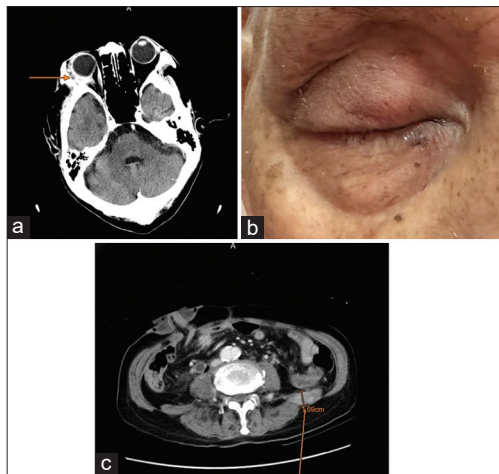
Brain computed tomography (CT) with contrast (a) and photo of the right eye (b) showing orbital tumor shrinkage after enfortumab vedotin (EV) and radiation therapy. Abdominal CT with contrast (c) showing partial response of muscular metastasis after EV
